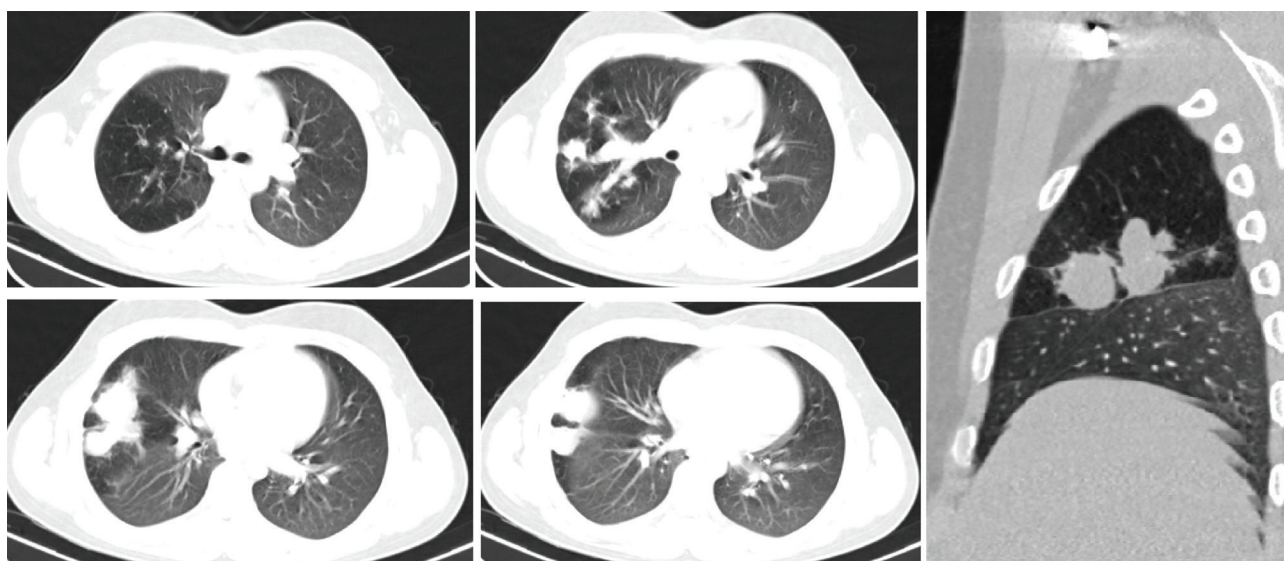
CT scan of the chest: evidence of congenital bronchial atresia.
